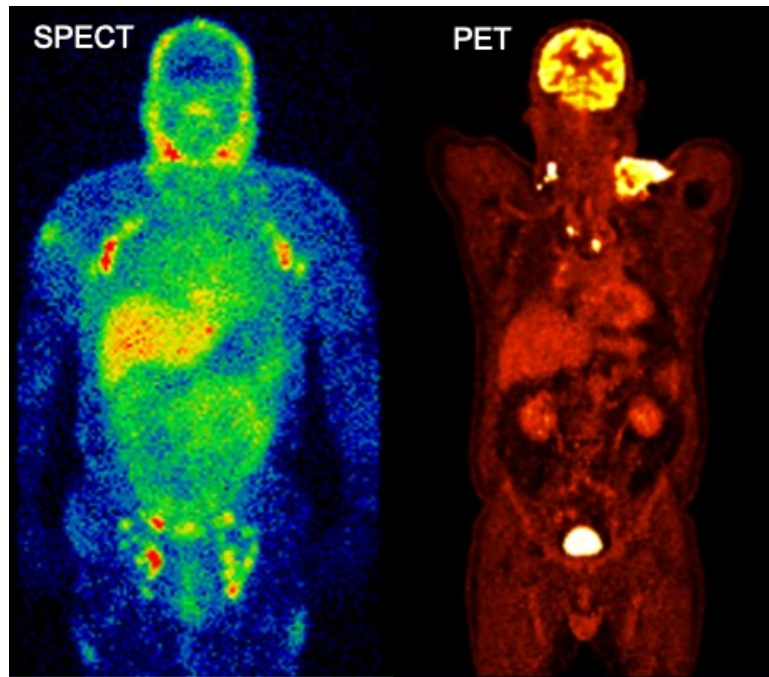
An example of a coronal whole-body SPECT and PET image showing the radiopharmaceutical distribution in the body. Note that SPECT imaging yields a relatively low image resolution (typically around 10 mm in clinical systems) compared to PET imaging
